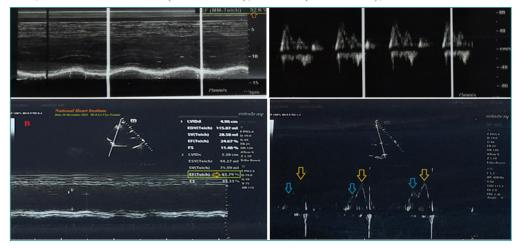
A. Echocardiography was done 33 days before the ICU admission showing a fair LV systolic function of an EF of 53% (golden arrow), grade II diastolic dysfunction, and akinetic apex (orange arrows) with apical to mid septum and anterior wall. B. Echocardiography was done just after CABG showing a good LV systolic function of an EF of 61% (golden arrow) and grade I diastolic dysfunction (light blue and orange arrows).
